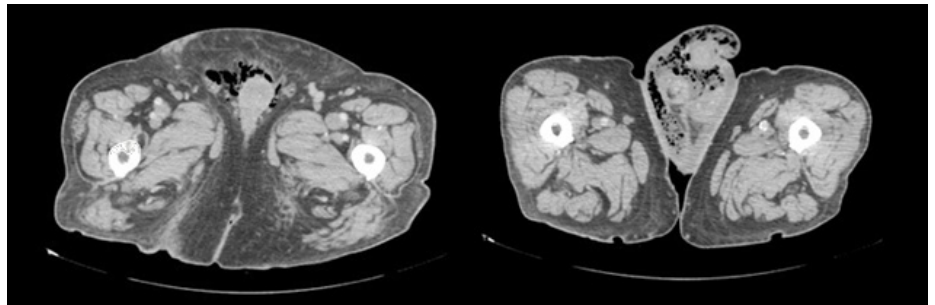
Mr. P.G.'s computed tomography scans of the abdomen and pelvis.
